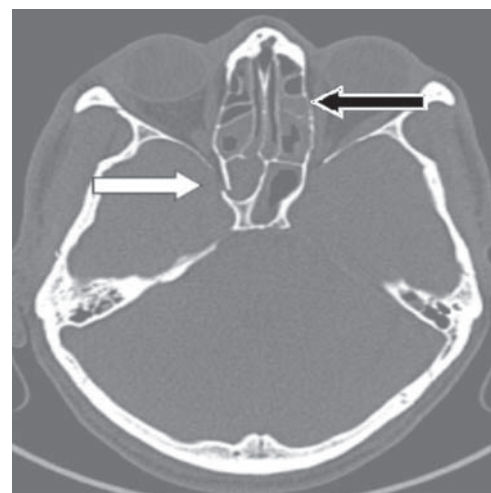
CT scan showing fracture of sphenoid (block arrow) and blood in ethmoid sinuses (empty arrow)
